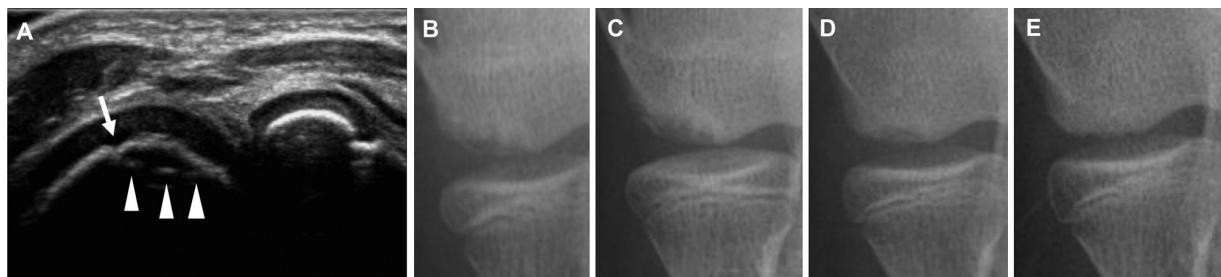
Stage I (radiolucent stage) osteochondritis dissecans of the humeral capitellum (radiolucent area). (A) Ultrasonographic image obtained during the initial screening (posterior long-axis view). Irregularity (arrow) and double floor line (arrowheads) were found on the capitellum. (B) Radiograph (45° flexed tangential anteroposterior view) obtained at the initial examination. (C-E) Radiographs obtained at 2, 6, and 10 months after the initial examination, respectively.
